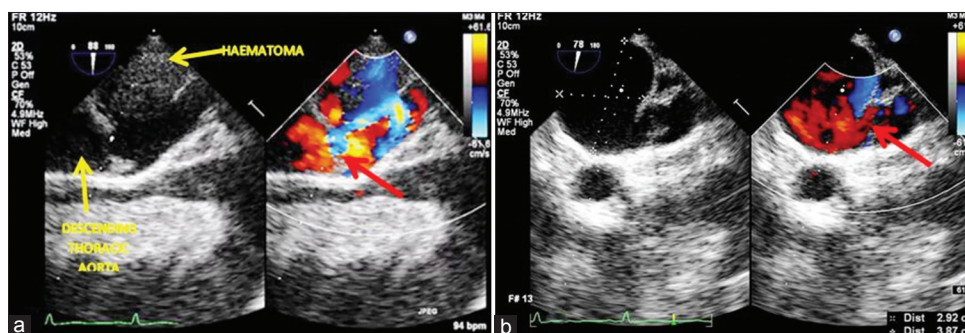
Transesophageal echocardiography-mid esophageal aortic (descending thoracic aorta) (a) short axis view and (b) long axis view showing turbulent flow entering the pseudoaneurysm (red arrow) and adjacent hematoma
